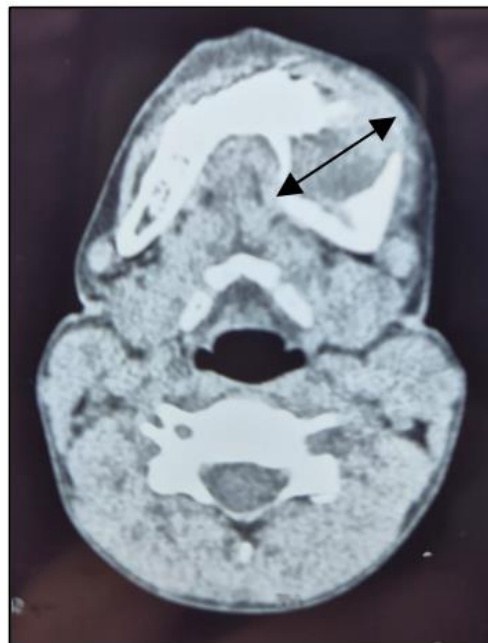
Facial CT Scan showing a left mandibular osteolytic tumoral process
